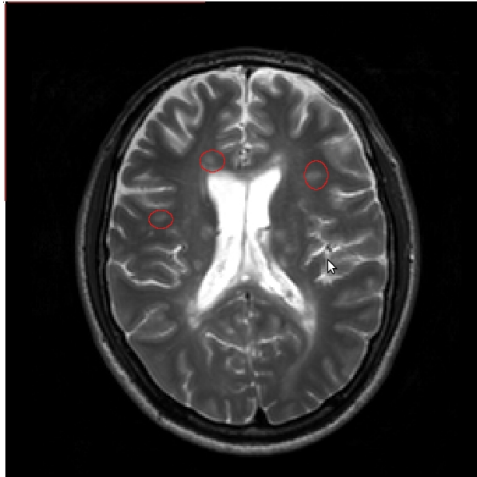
MRI scan shows MS lesions in a patient (circled in red).
